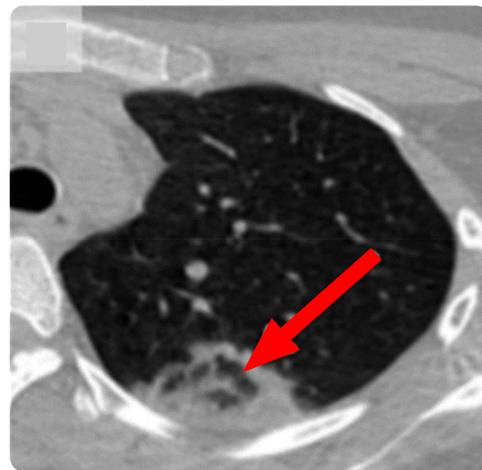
Reverse halo sign. Axial CT scan. 22-year-old woman. An area of frosted glass opacity is observed with a dense consolidation ring towards the left upper lobe (arrow). This finding corresponds to the sign of the reverse halo. Source: Taken with permission of publication of Bernheim and collaborators. (45).
